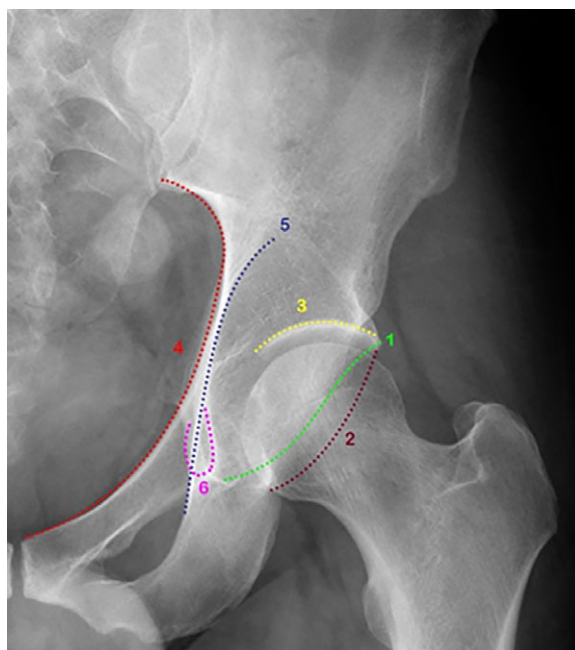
Anteroposterior (AP) pelvis radiograph
